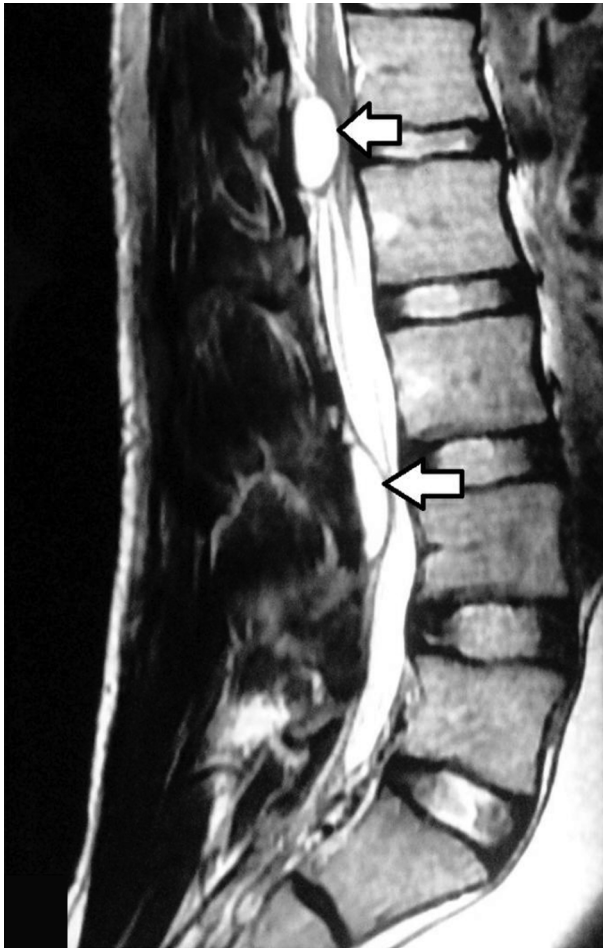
Lumbosacral T2W Sagittal MRI Showing 2 Oval-Shaped Cystic Lesions (Arrows) with Regular Contours in the Dorsal Extradural Space at L1 and L3-4 Vertebral Levels, Causing Conus Medullaris Compression at L1 level
